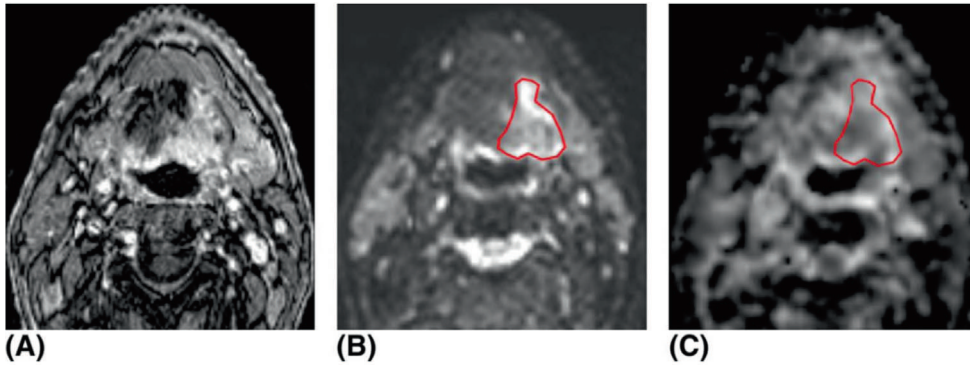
(A-C) Images in a 68-year-old man with a human papillomavirus (HPV)-negative oropharyngeal carcinoma. (A) Axial post contrast T1-weighted MRI with fat suppression shows an infiltrative lesion centered in the left tongue base with anterior extension in the floor of the mouth. (B) Axial diffusion-weighted image ($b=800$ s/mm²) showing somewhat increased signal intensity in the tumor. This signal intensity is far less than in HPV-positive carcinoma shown in Figure 3. (C) Corresponding axial apparent diffusion coefficient map showing less signal loss in comparison to HPV-positive carcinoma, indicative of a higher apparent diffusion coefficient value.
